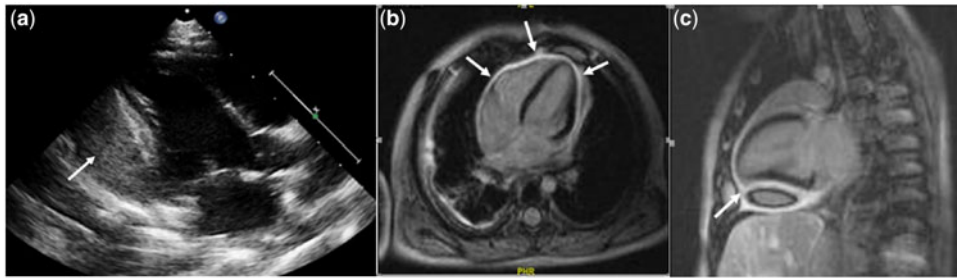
a: Parasternal long axis view on echocardiography depicting pericardial fluid collection posterior to the left ventricular free wall with thickening of the pericardium (arrow) b&c: CMRI images with pericardial late gadolinium enhancement (LGE) changes especially at the antero-inferior aspect of the ventricles (arrows). There was also pericardial collection at the left inferolateral and inferior part of the heart that consisted of blood products.
